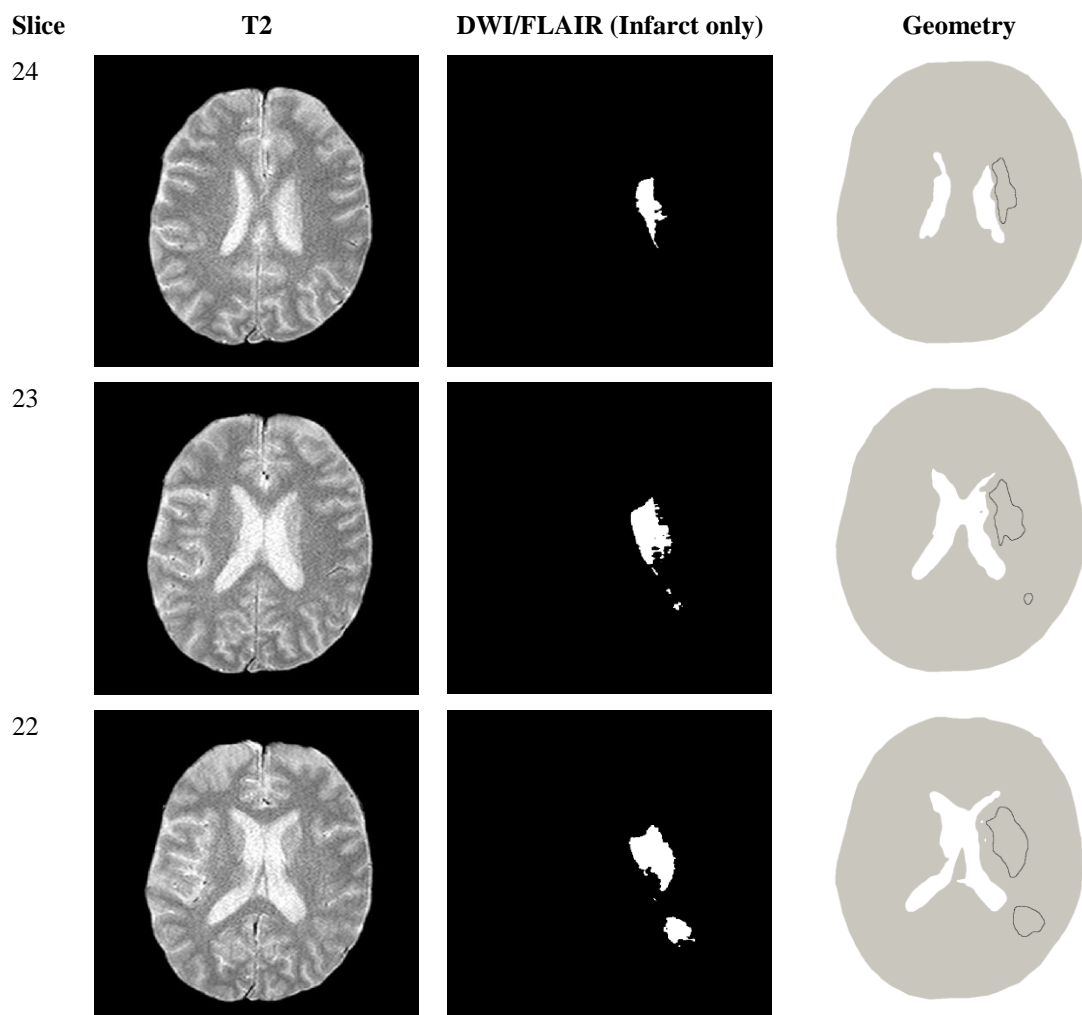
The MRI images and geometry of slices 22 to 24 of patient 2.
